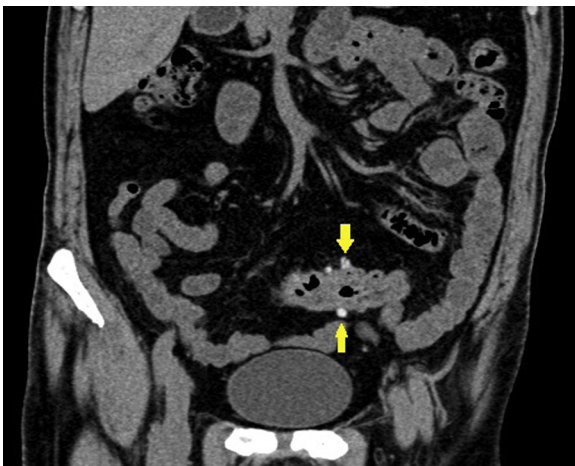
Fifty-six year old male patient with left flank pain. CT stone protocol shows small diverticula in the sigmoid colon (arrows). No stones were found.
